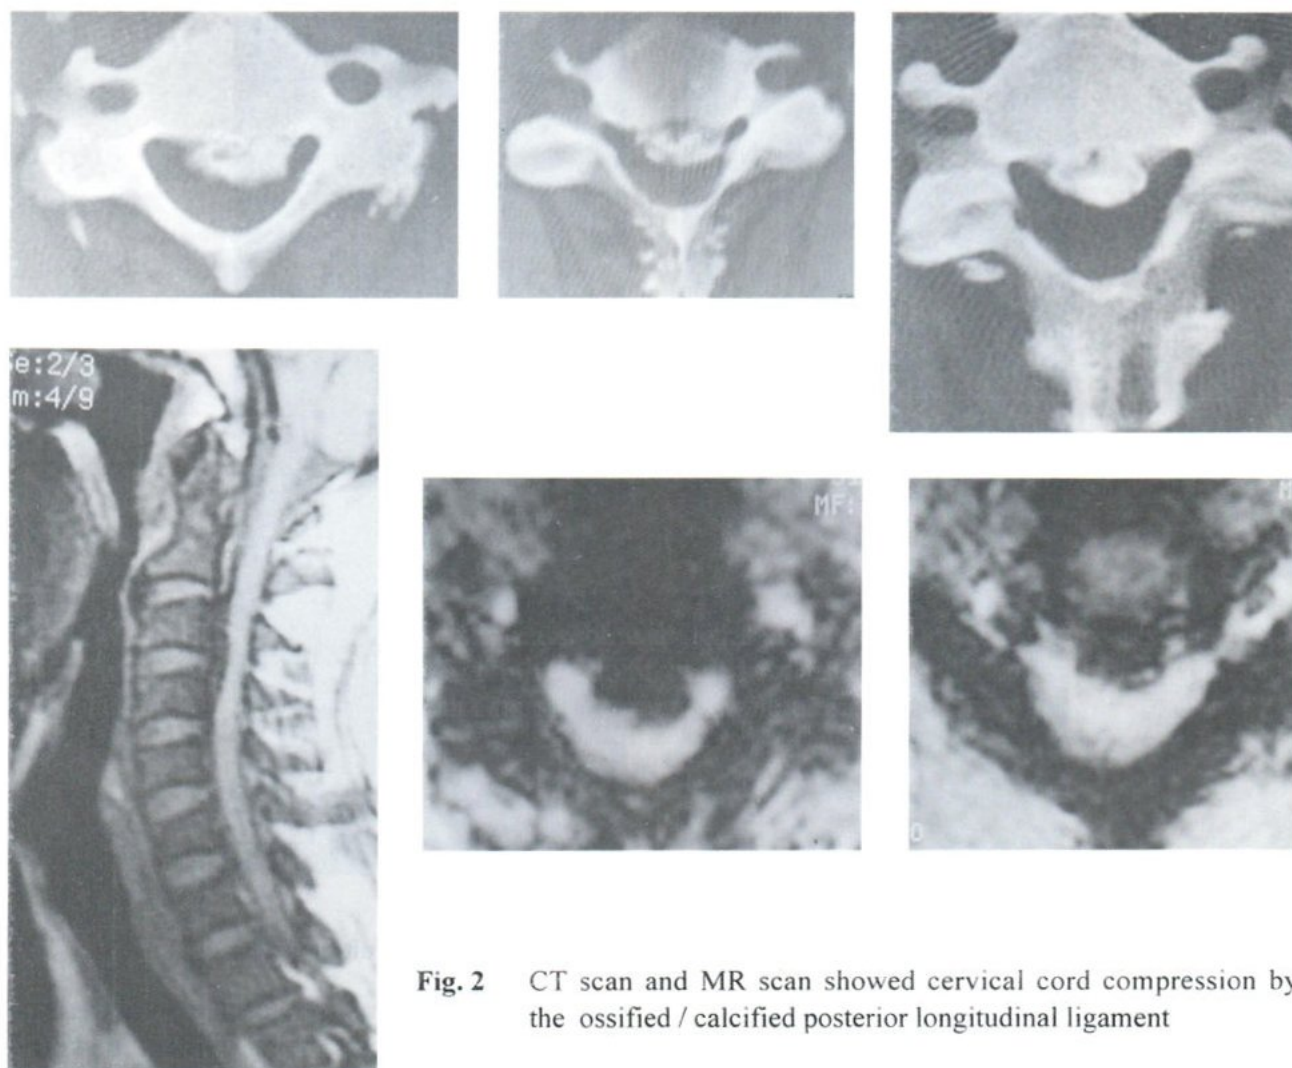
CT scan and MR scan showed cervical cord compression by the ossified / calcified posterior longitudinal ligament
